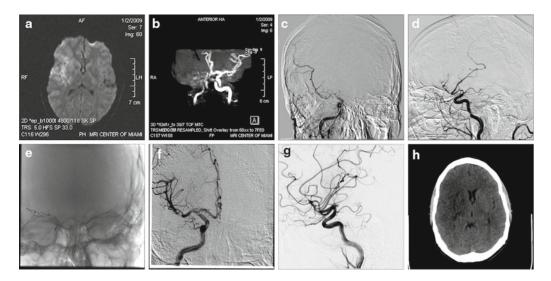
A 28-year-old male with acute left sided weakness while jogging. NIHSS was 16 when 5.5 h from symptom onset. He received IV tPA (0.9 mg/kg) and mechanic thrombectomy. He was discharged with NIHSS of 3. (a) DWI showed restrictive diffusion in R MCA distribution.
